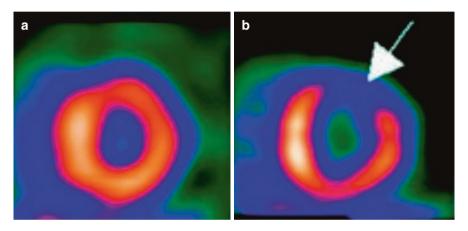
Short-axis image of the left ventricle during SPECT imaging at rest (a) and after stress (b). A reversible perfusion defect is observed in the anterolateral wall (white arrow) indicative of coronary ischaemia. Reproduced from Ghersin et al. (2006). Circulation; 114:e237–239 [32]
